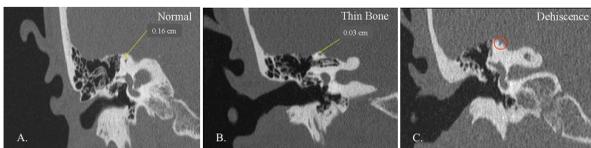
Coronal CT scans of the roof of the SSC and the cranial cavity showing normal compared to SSCD
